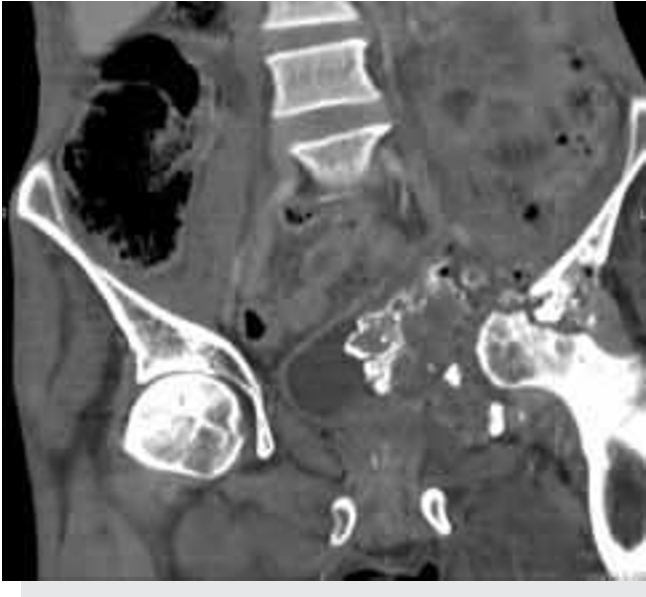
Contrast enhanced abdomen CT showing the iliac bone fracture.
